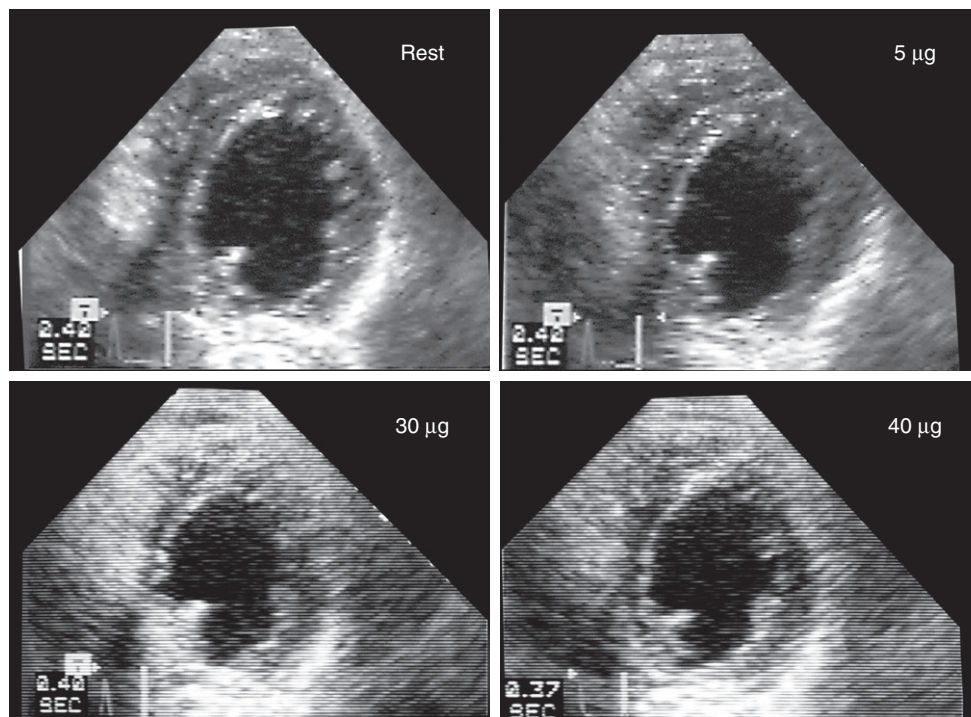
Dobutamine stress echocardiography shows a biphasic response with improvement of contraction in the inferior segment with a low dose of dobutamine (5 µg/kg/min) and dyskinesia of the same segment at a higher dose (30 to 40 µg/kg/min), showing myocardial viability and ischemia, respectively.
